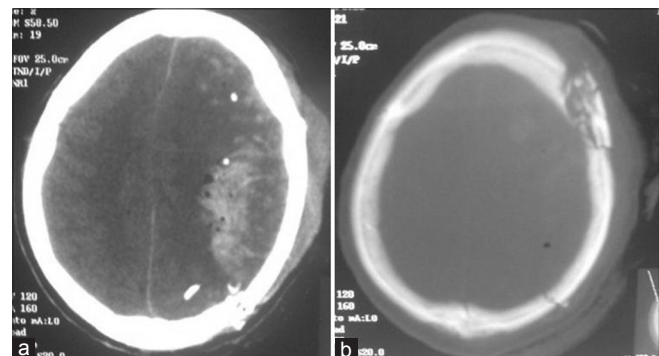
Cranial CT scan, brain and bone windows
